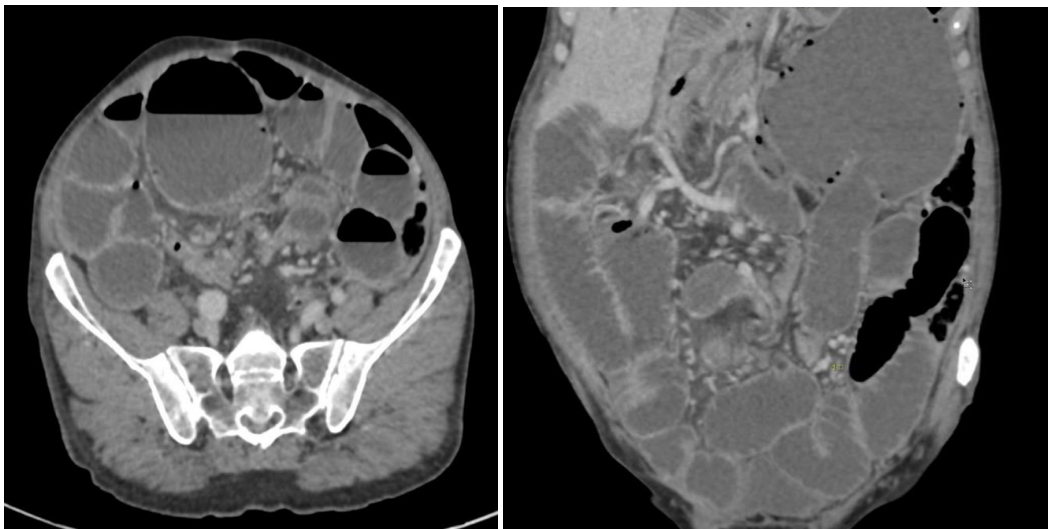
CT sections showing the intestinal flange associated with the cecal volvulus
